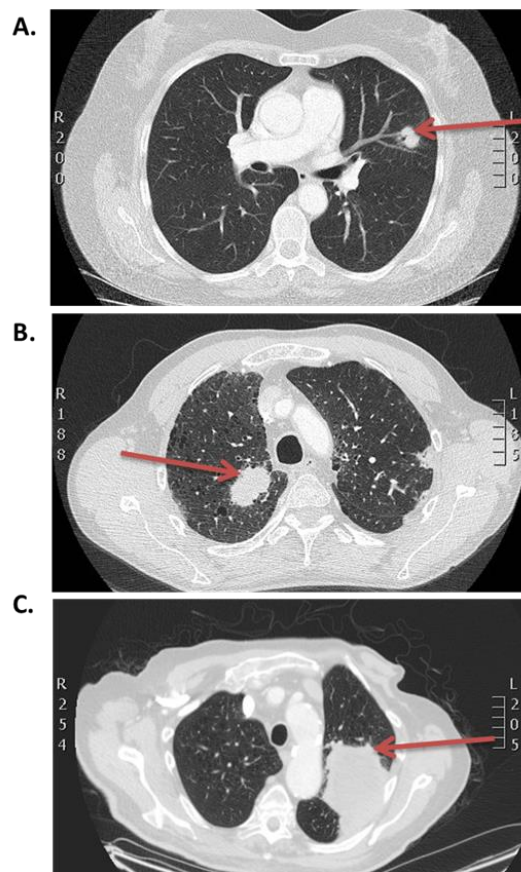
CT Images of patients tumour. CT mass were interrogated against DNA Integrity Index, by means of CT scans to assess tumour size. (A) Stage IA Non-mucinous Adenocarcinoma of the Lung; (B) Stage IIB Adenocarcinoma of the lung; (C) Stage IV NSCLC. Red arrow denoted tumour.
